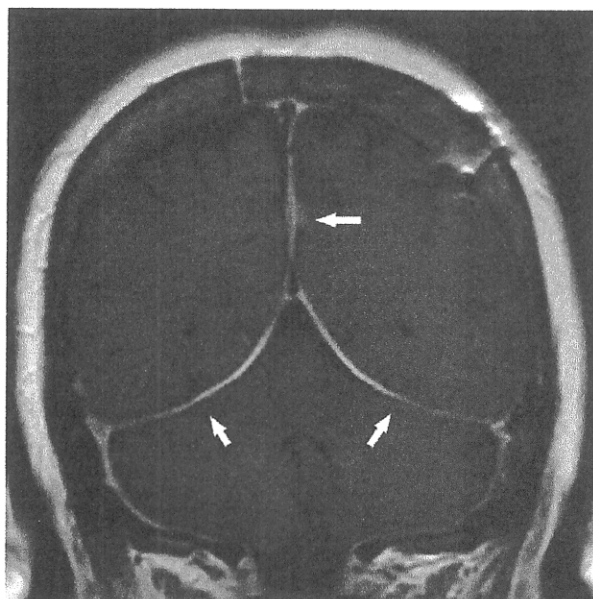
Gadolinium-enhanced T1-weighted magnetic resonance imaging performed after treatment revealed pachymeningeal thickening and linear enhancement of the dura mater (arrow).
